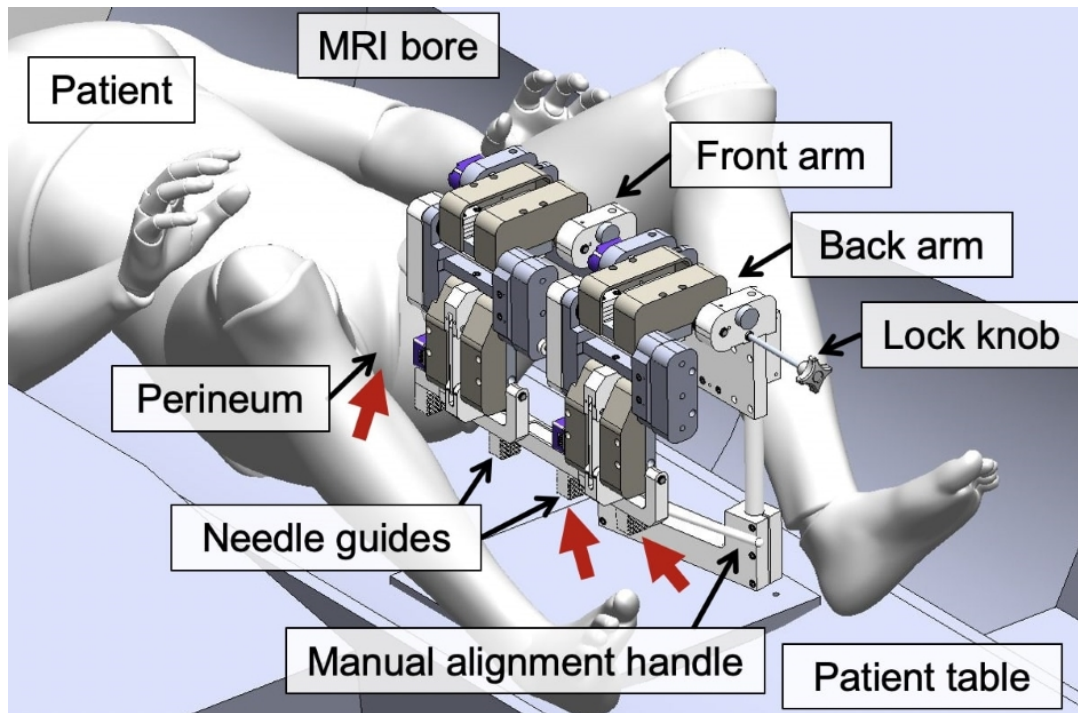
Computer-aided design (CAD) isometric model of the MRI-compatible mechatronic needle guidance system for prostate focal laser ablation (FLA) needle intervention. Encoders are identified by purple casings. Motors are hidden inside the device. Red arrows indicate where the needles are inserted: first through the guide at the rear of the system, then through the rest of the needle guides, and finally into the perineum.
